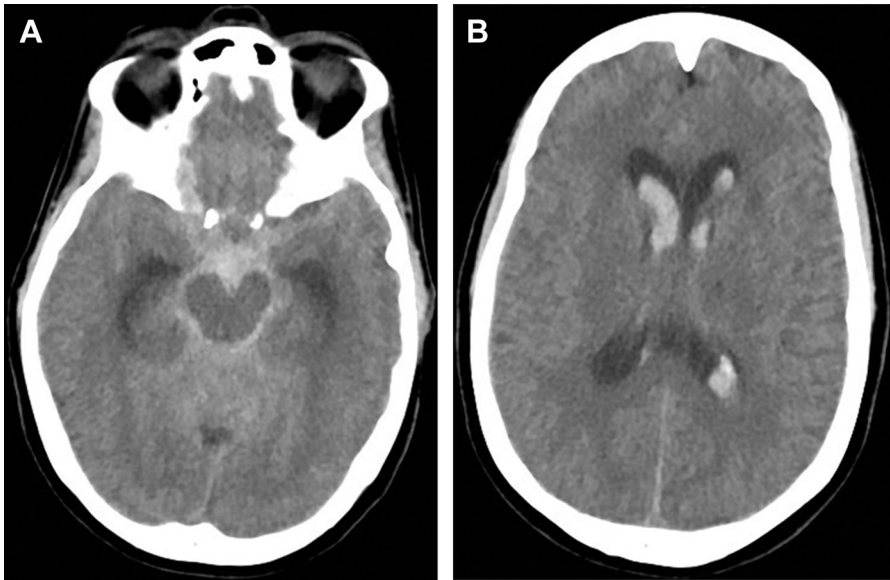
(A and B) Noncontrast enhanced computed tomography of the head; a classic example of subarachnoid hemorrhage with intraventricular extension. Note the starfish appearance of the hyperdensity caused by the blood in the subarachnoid space. (Courtesy of Michael Abraham MD, MS, Baltimore, MD.)
